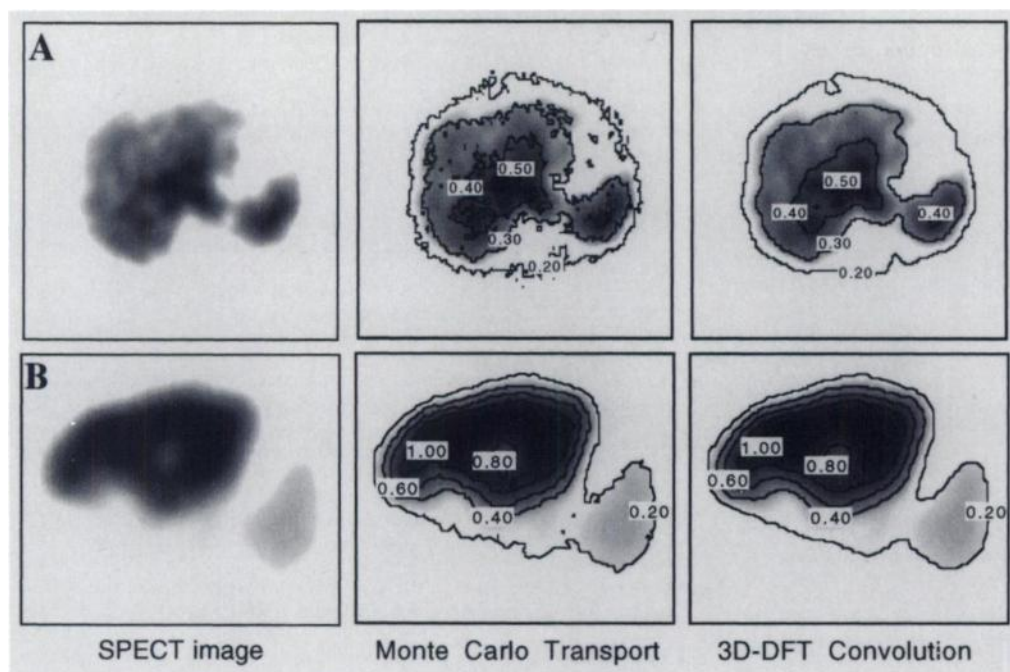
Comparison of MCT and 3D-DFT convolution isodose-rate contours (cGy/hr). SPECT slices of the liver and spleen of two patients who had undergone ^{131}I RIT.
